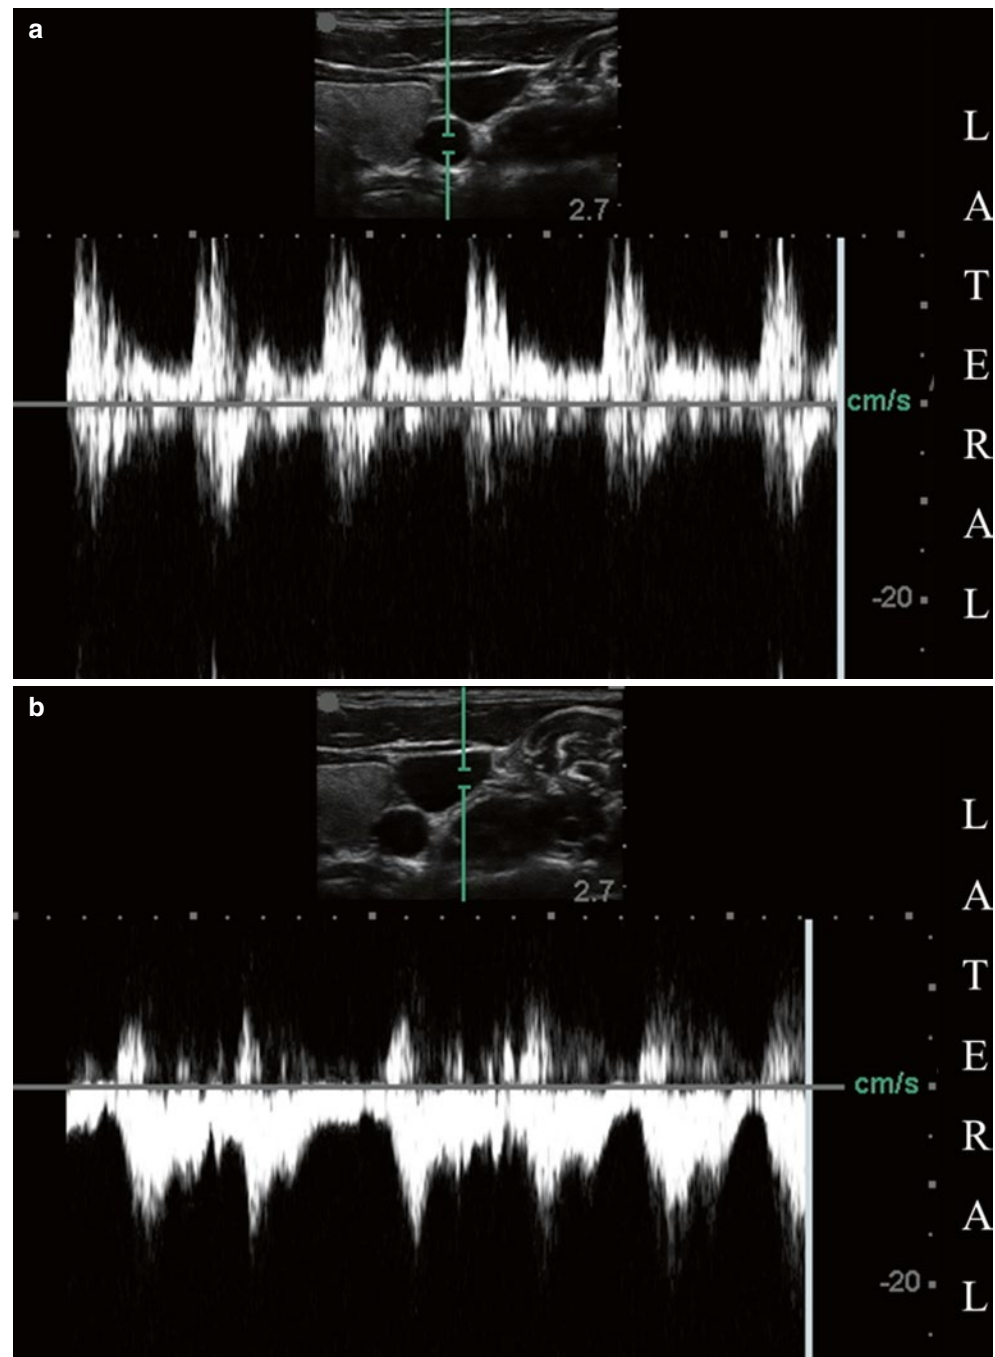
Pulse-wave Doppler showing an arterial (a) and a venous waveform (b) in femoral artery and vein, respectively (Reproduced with permission from www.regionalfortraînees.com)
